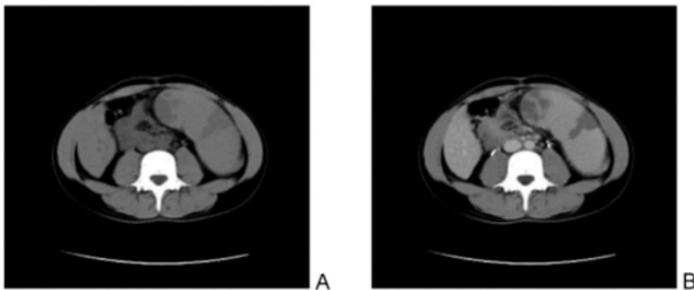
A) A non-contrast CT scan showing an enlarged spleen (splenomegaly) with wedge-shaped regions (showing splenic infarction) of low density. Low density areas show ischemic zone with reduced blood flow. (B) A contrast-enhanced CT scan to highlight blood flow. In this scan, healthy tissue regions will light up, and unhealthy tissue regions will not appear darker indicating this splenic tissue is not viable [11].
